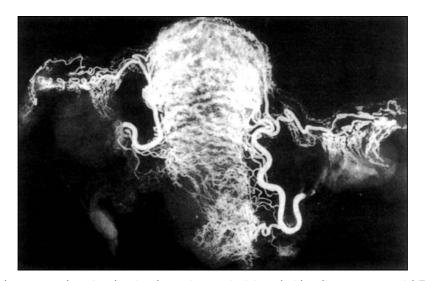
A radiograph of the uterus and ovaries, showing the uterine arteries injected with radio-opaque material. The right uterine artery was damaged and displaced during hysterectomy but the descending cervical branch is well seen on the left side. Note the characteristic spiral shape of the coronary arteries in the myometrium and of the arterioles in the ovary. The ovarian arteries were not injected and the radiograph indicates the free anastomosis between the uterine and ovarian vessels. This component of the blood supply can be diminished after panhysterectomy and explains the early cessation of menstrual function in some of these women
